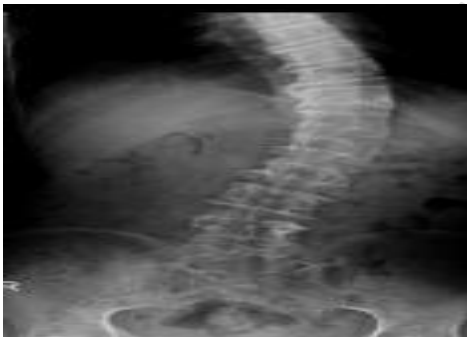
X-ray of spinal chord
